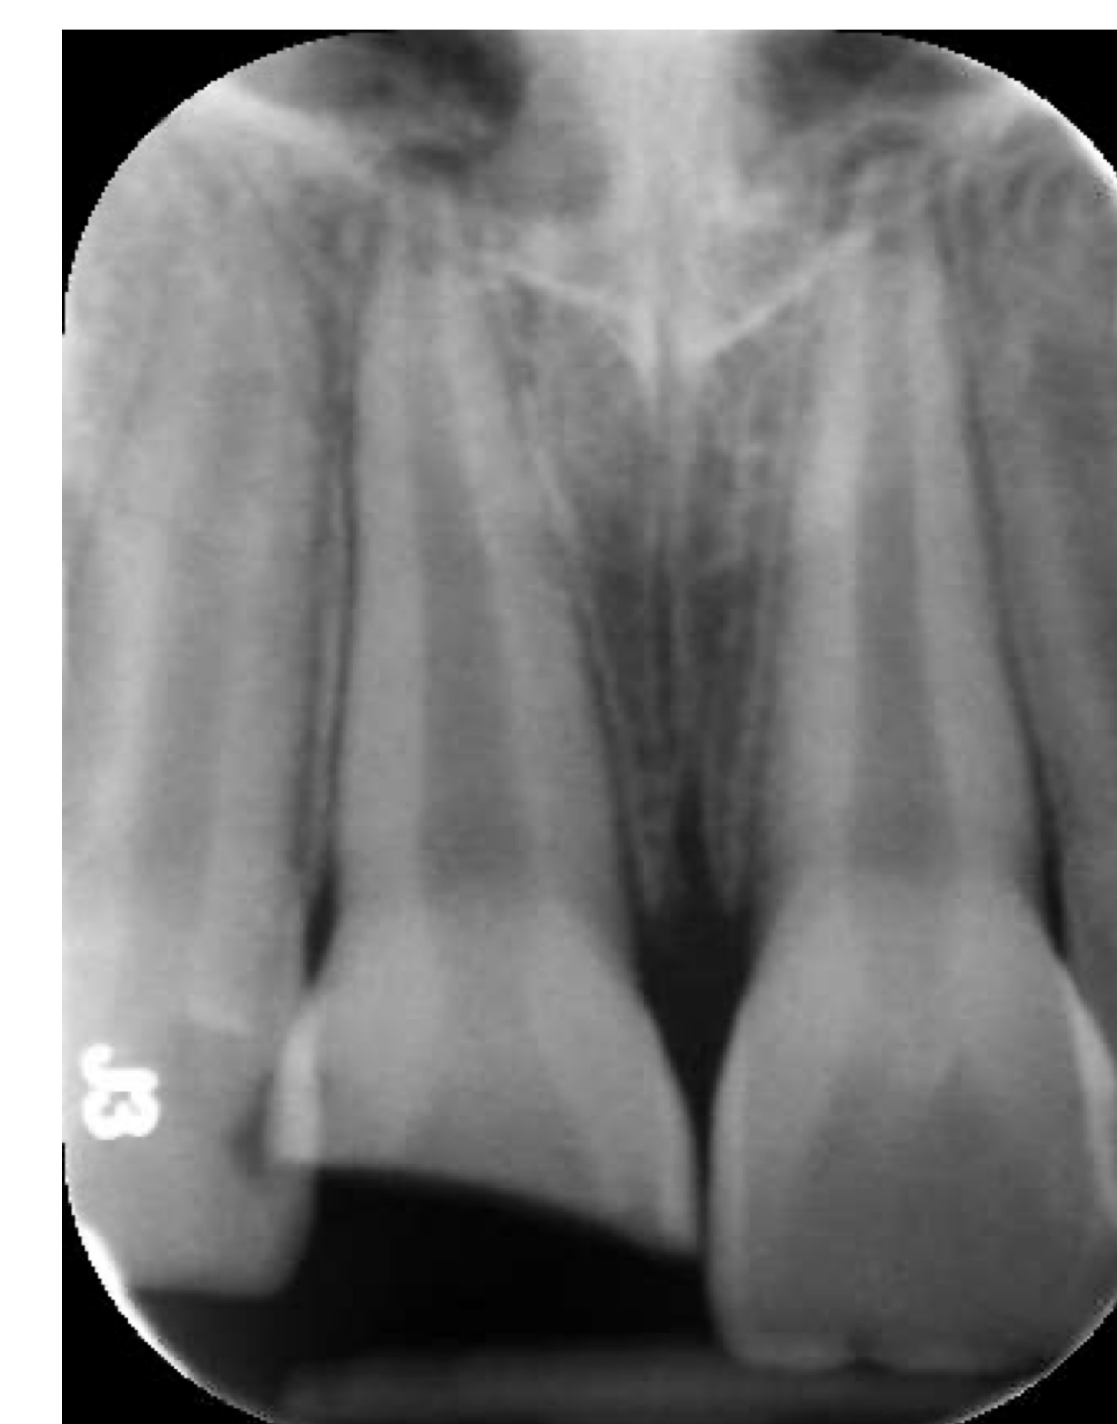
Periapical radiograph taken on emergency visit
